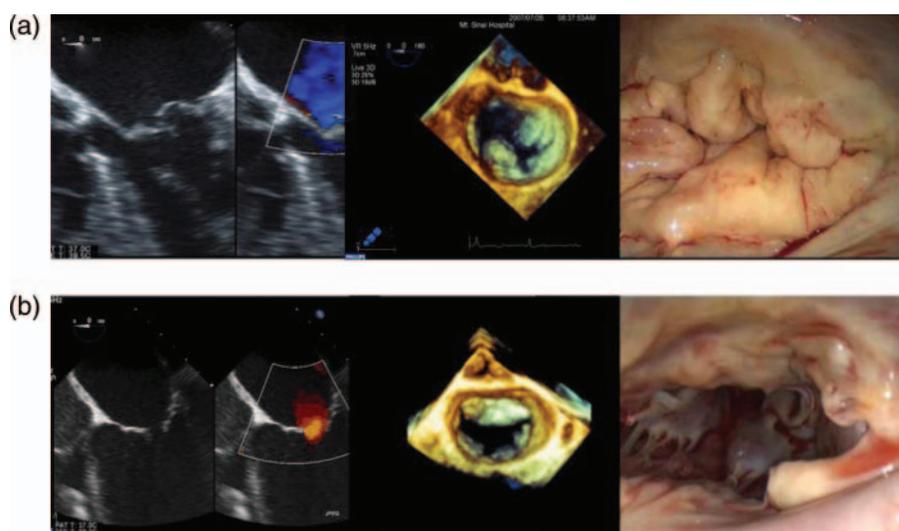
From left to right, 2D transoesophageal echocardiography, 3D echocardiographic reconstruction and intra-operative views of a mitral valve showing (a) Barlow's disease with multisegment bileaflet prolapse in a giant valve and (b) ischaemic mitral disease with posterior leaflet displacement of the posteromedial papillary muscle resulting in restricted motion particularly of the posterior leaflet.
